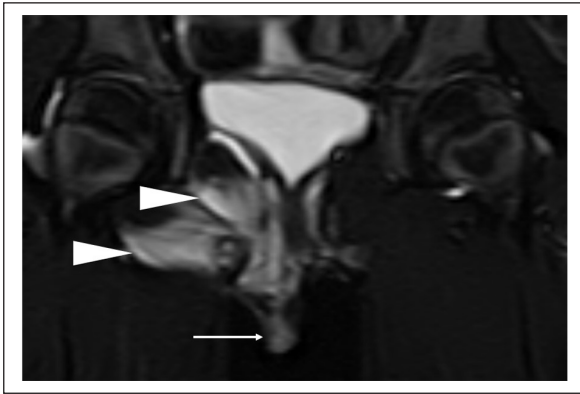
Short tau inversion recovery image, coronal. Diffuse high intensity of the right obturator internus and externus muscles (arrowhead) and the right labium majus (arrow) muscles by pelvic magnetic resonance imaging on hospital day 1.
